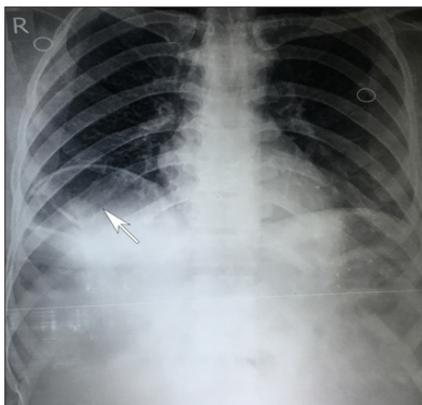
An erect chest radiograph showing air under diaphragm (arrow)
